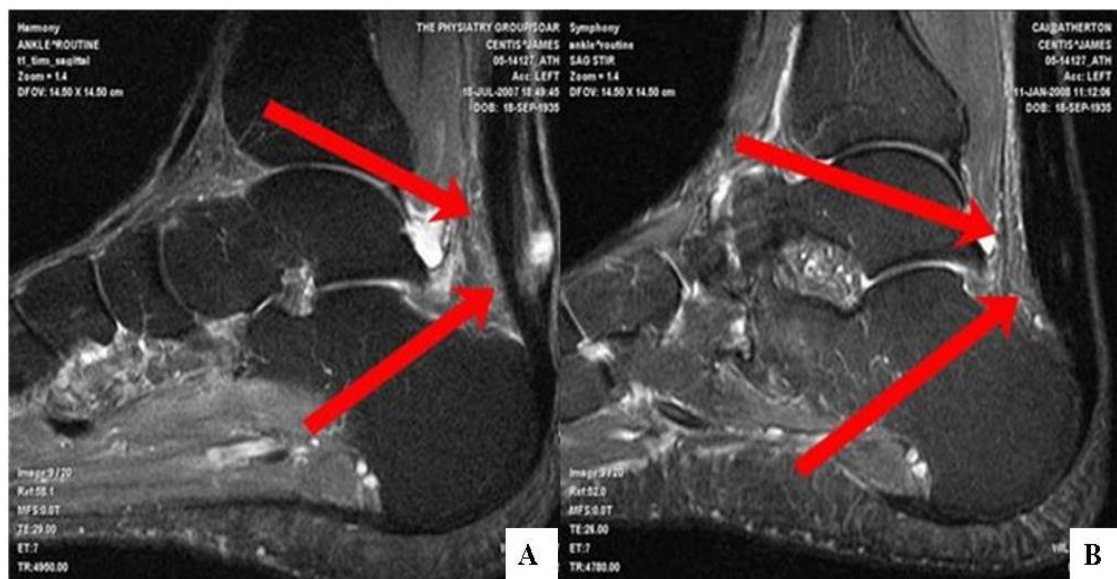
Achilles MRI before and after PRP treatment. A) MRI before PRP injection, partial Achilles tear. B) MRI 4 months after PRC, healing of partial tear. Adapted from Mishra *et al.*, 2009¹⁹³.
